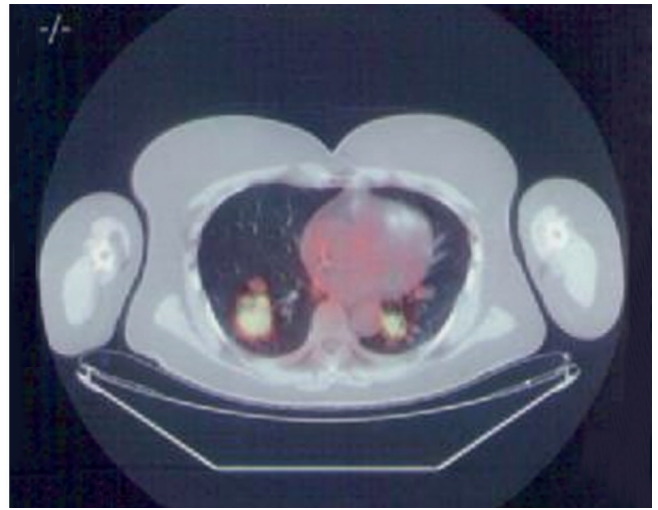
Positron-emission tomography (PET-CT) scan after 6 cycles of treatment with trabectedin, showing tumor activity in metastases.
